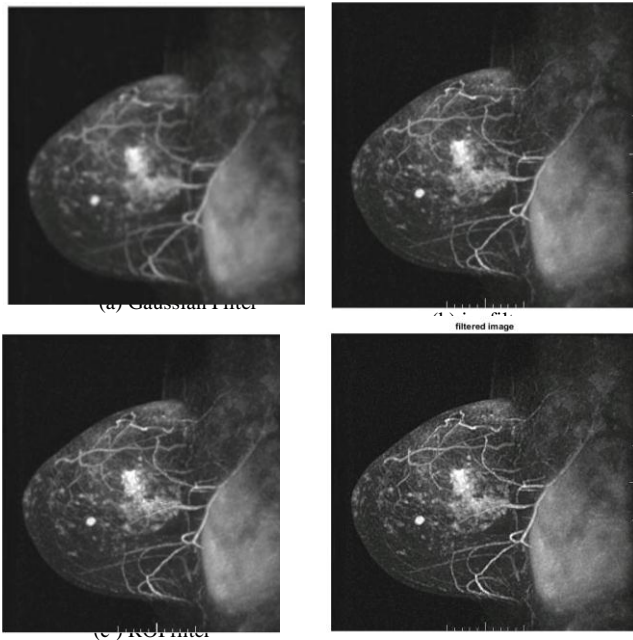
Preprocessing of MRI images by using filter
